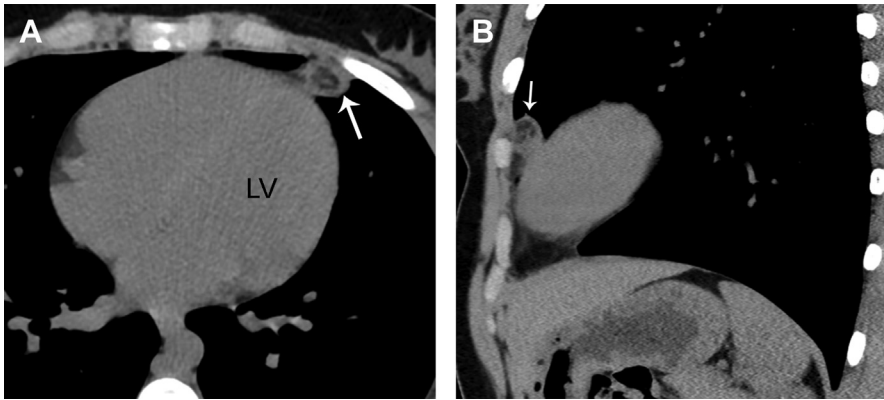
Pericardial and epi-pericardial fat necrosis in a 20-year-old woman who presented to the emergency department with acute chest pain. (A) An unenhanced axial CT scan of the chest demonstrates an oval mass (*arrow*) abutting the left ventricle (LV). There is a soft tissue ring surrounding a fat-containing center and associated mild stranding of the adjacent mediastinal fat. These imaging findings are characteristic of pericardial and epi-pericardial fat necrosis. (B) An unenhanced sagittal reformation demonstrates the oval mass (*arrow*) with stranding of the adjacent mediastinal fat.
